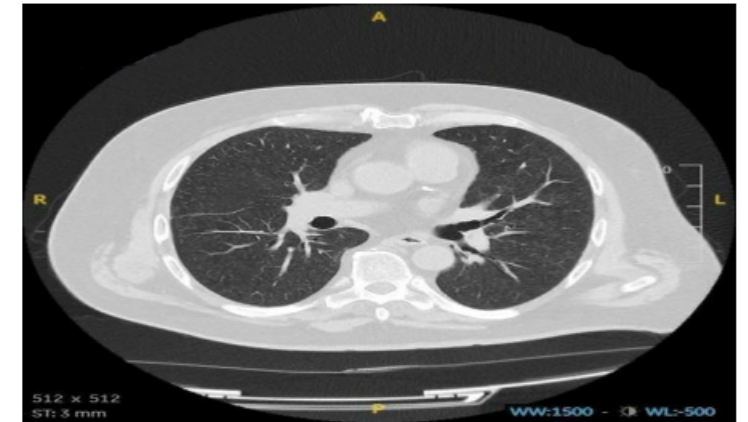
Repeat chest CT three months post-admission
